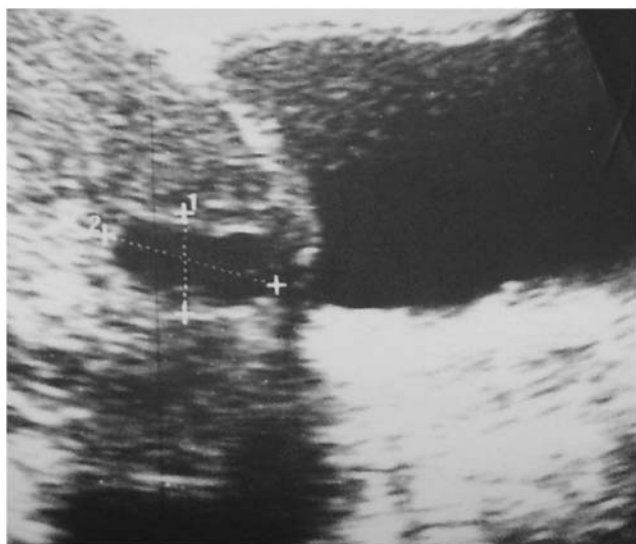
Sonographic view of a cesarean scar pregnancy shows discontinuity in the anterior wall of the uterus.
